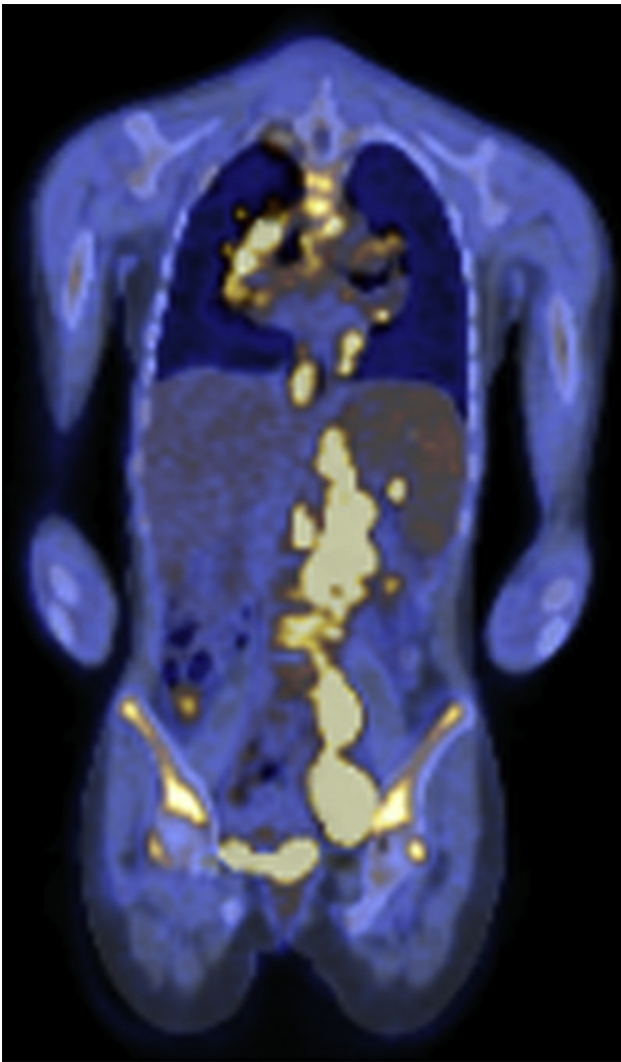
PET-CT image demonstrating Hodgkin lymphoma involving the left internal iliac node basin.
